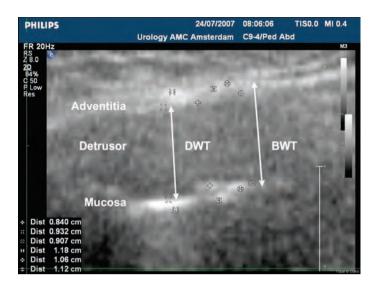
Ultrasound imaging of the anterior bladder wall by suprapubic positioning of a high frequency ultrasound array. The mucosa and adventitia of the bladder appear as hyperechogenic (white) thin lines, whereas the detrusor appears as a hypoechogenic (grey) bar between the hyperechogenic mucosa and adventitia. The measurement distance from the outside border of the mucosa until the outside border of the adventitia represents bladder wall thickness (BWT), whereas the distance from the inner border of the mucosa until the inner border of the adventitia represents detrusor wall thickness (DWT).
